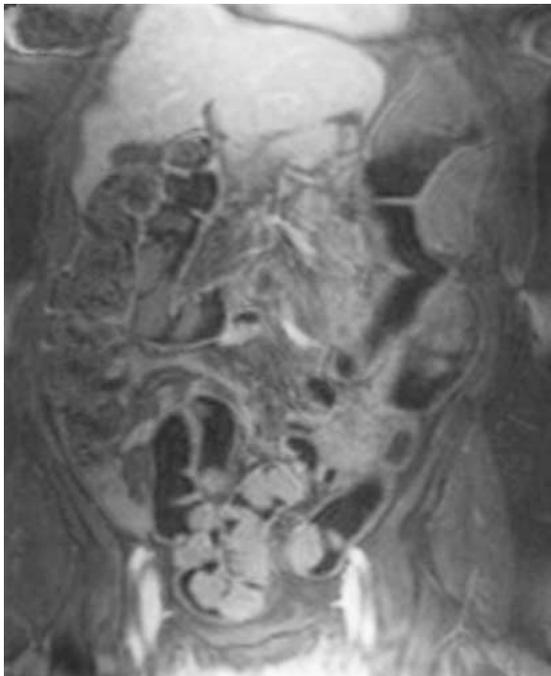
Coronal image of 3D T1-weighted dataset 60 s after injection of contrast material. A relatively dark stool signal is observed in the ascending colon, whereas the stool signal in the distal colon seems more dehydrated (visual impression) and hyperintense.
